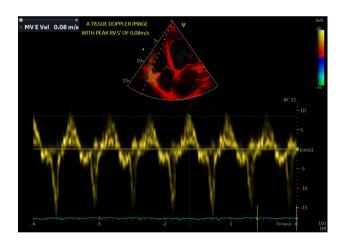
Tissue doppler image echocardiography of one of the participants showing measurement of the right ventricular peak systolic velocity (RV S'=0.08 m/s). E vel, E velocity, HR, heart rate.
